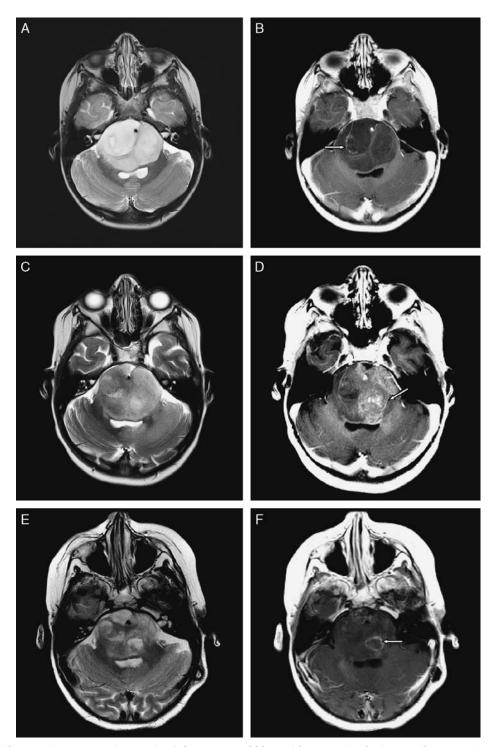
Axial magnetic resonance images (MRI) for a 5-year-old boy with progressive brainstem glioma. A, T2-weighted image obtained at initial diagnosis shows diffuse brainstem enlargement by a diffuse intrinsic pontine glioma, with marked hyperintensity of the pons, compression of the fourth ventricle, and characteristic engulfment of the basilar artery by the tumor. B, Postcontrast T1weighted image at initial diagnosis shows thin rim of enhancement on right (arrow). C, Axial T2-weighted image obtained 13 months later, after initial radiation and chemotherapy, before reirradiation, shows significant improvement after initial radiation and chemotherapy but progression compared with a previous magnetic resonance images (not shown); (D) postcontrast T1-weighted image obtained at the same time shows progressive enhancement on left with a cavitary focus (arrow) with the resolution of the rightsided enhancement. E, Axial T2-weighted image obtained 2 months later, after reirradiation, shows the improvement of the T2 hyperintensity; (F) postcontrast T1-weighted image obtained at the same time also shows the improvement in enhancement and the reduction in size of the cavitary focus with margin enhancement (arrow).
